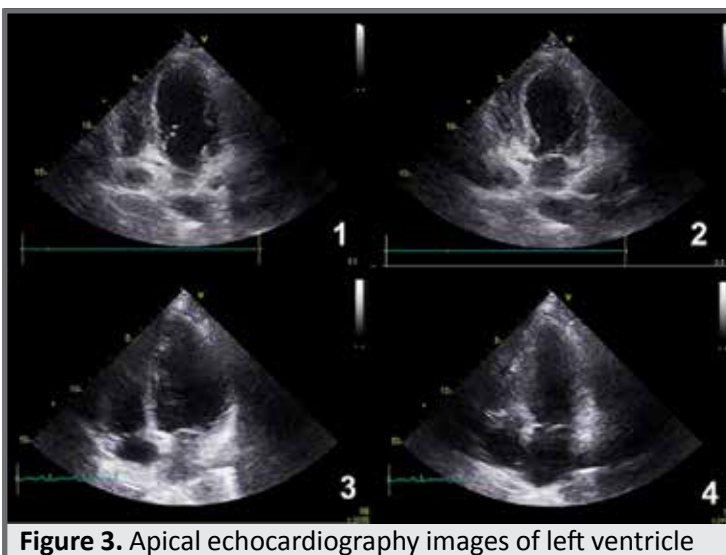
Apical echocardiography images of left ventricle
